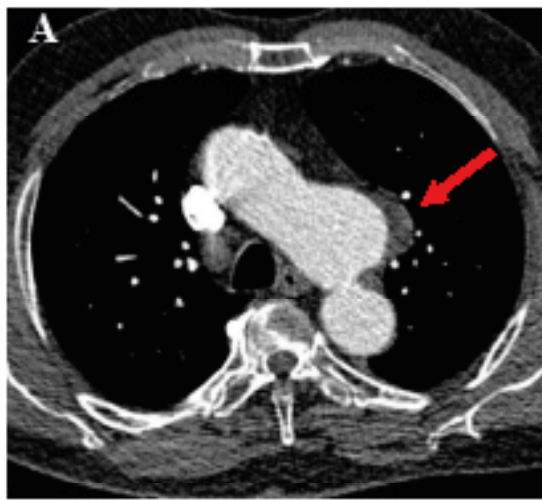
(A) Axial, (B) sagittal, and (C) coronal reformatted images of CTA thorax showing a wide neck aortic arch saccular aneurysm with peripheral mural thrombus (solid red arrow) and its dome pointing inferiorly protruding to the aortopulmonary window along the course of the left recurrent laryngeal nerve and compressing onto the left proximal main pulmonary artery (red dotted arrow).
